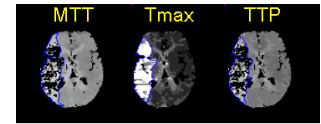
Use of clustering, island statistics and DWI feedback results in reliable PWI lesion segmentation (MTT lesion = 255 cc, T_{max} lesion = 215 cc and TTP lesion = 224 cc)
